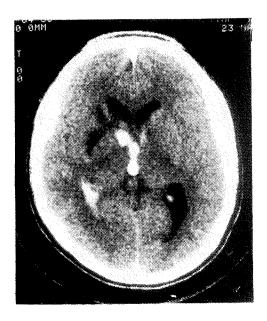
Unenhanced CT scan showing hemorrhage in Right basal ganglia with blood also in third ventricle and right occipital horn. Evidence of previous hemorrhage (radiolucent area lateral to this hemorrhage) is also seen.
